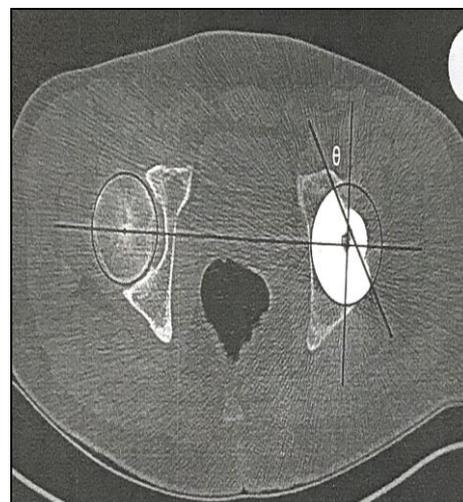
Measurement of the anteversion of the acetabular component on CT scan
